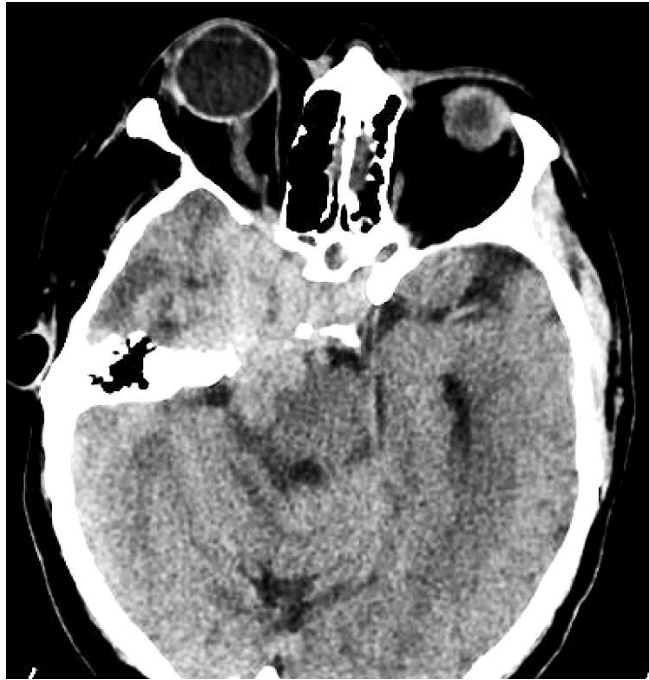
Cranial CT scan in axial view. The right ocular proptosis is evident, as well as the posterior tumour extension.
